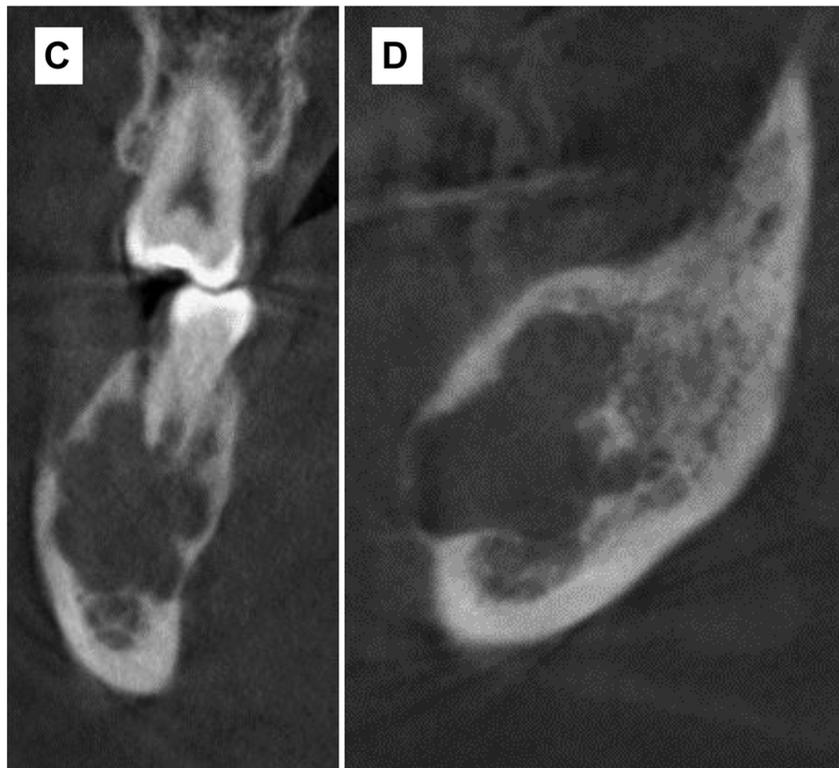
Recurrence of a giant cell lesion of the lower jaw in neurofibromatosis type 1 in cone beam computed tomography (cropped images, right side of bone depicted). A) Osteolysis of the mandible with thinning of the vestibular cortical bones. B) Root apex of the second molar in the lesion (A and B: axial section). C) Multiple lobulated intraosseous lesion (coronal section). D) The lobulated lesion extends caudally to the nerve canal (sagittal section).
